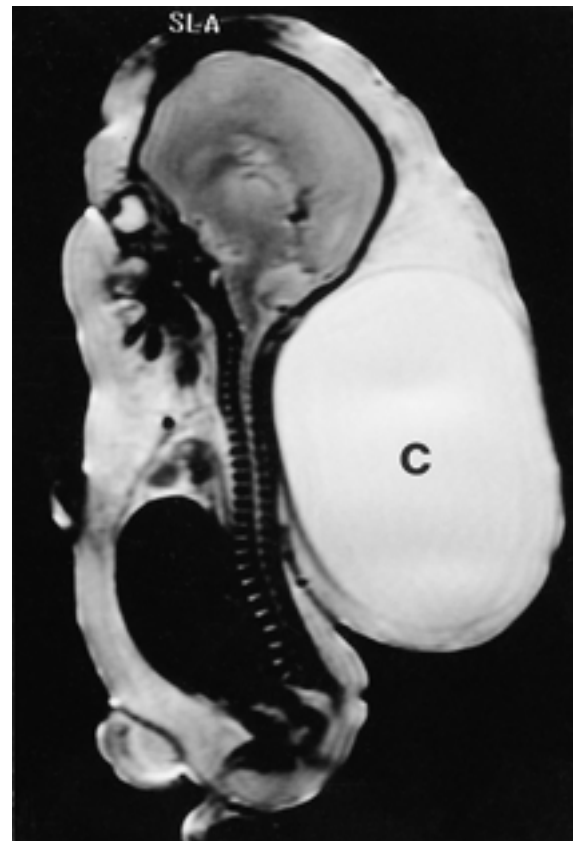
MR image of a fetus with large cystic hygroma. T2-weighted sagittal image shows a huge cyst (C) in the fetal neck and back. The entire fetal subcutaneous tissues are thickened due to associated lymphedema.
